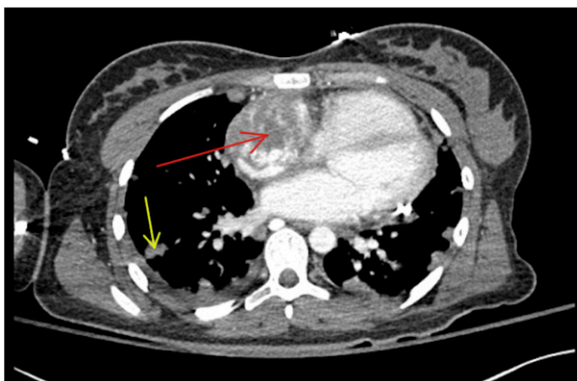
Patient's chest computed tomographic scan, axial view; red arrow indicates the primary tumor, and yellow arrow indicates lung metastases.
